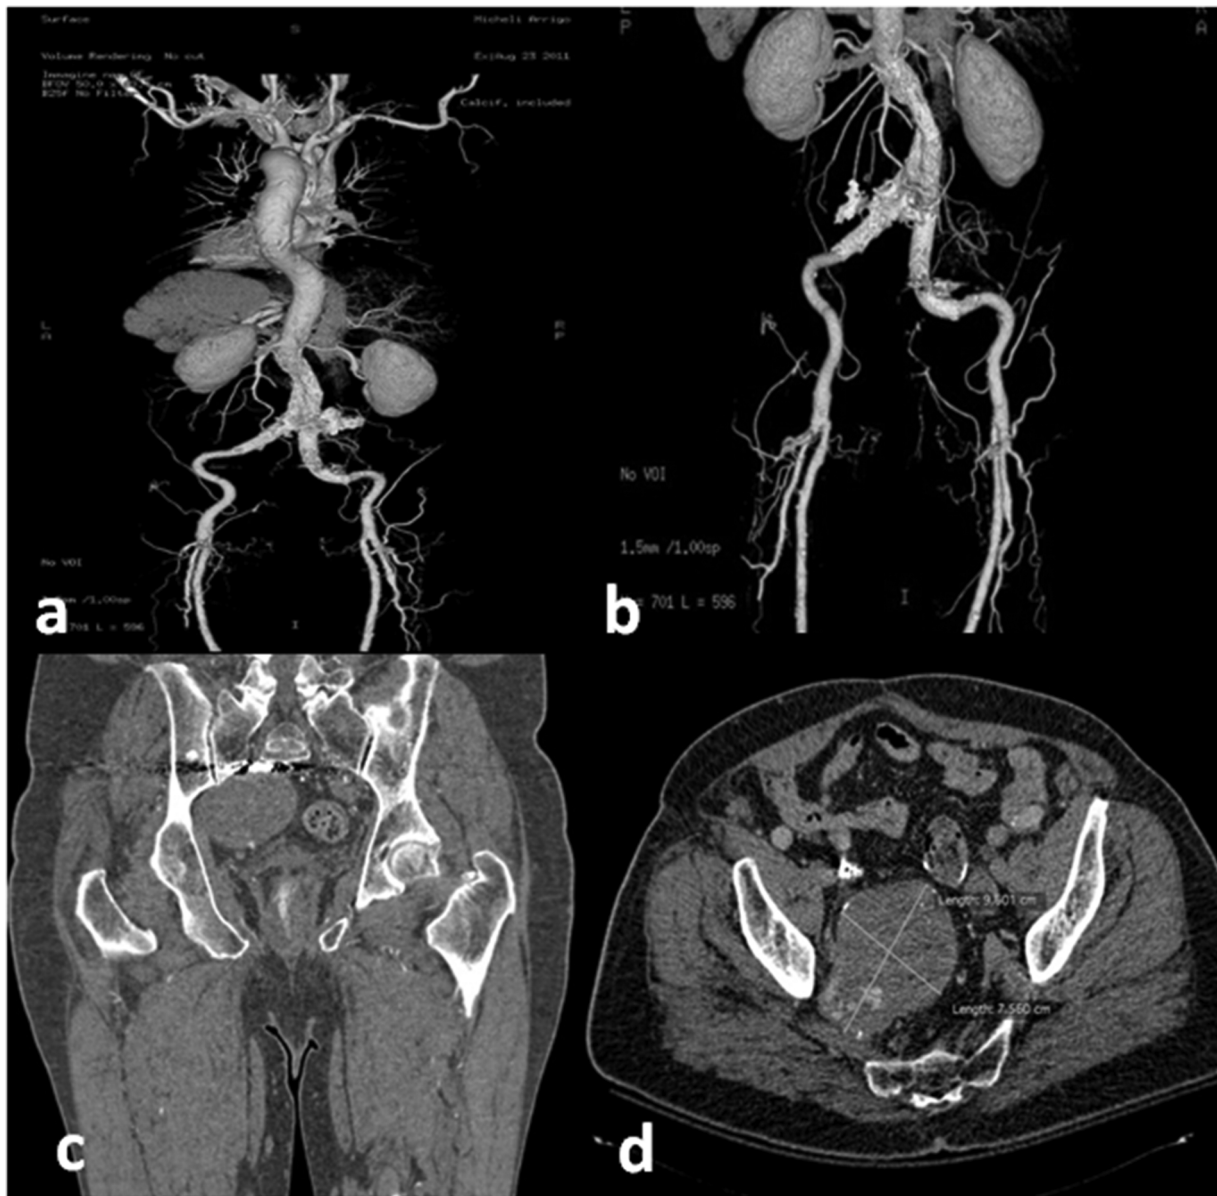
CT surveillance imaging after Endovascular Aneurysm Repair (EVAR); (a) and (b) Volume-rendered (VR) images, (c) coronal and (d) axial CT images demonstrate a right hypogastric aneurysm, without evidence of endoleak.
